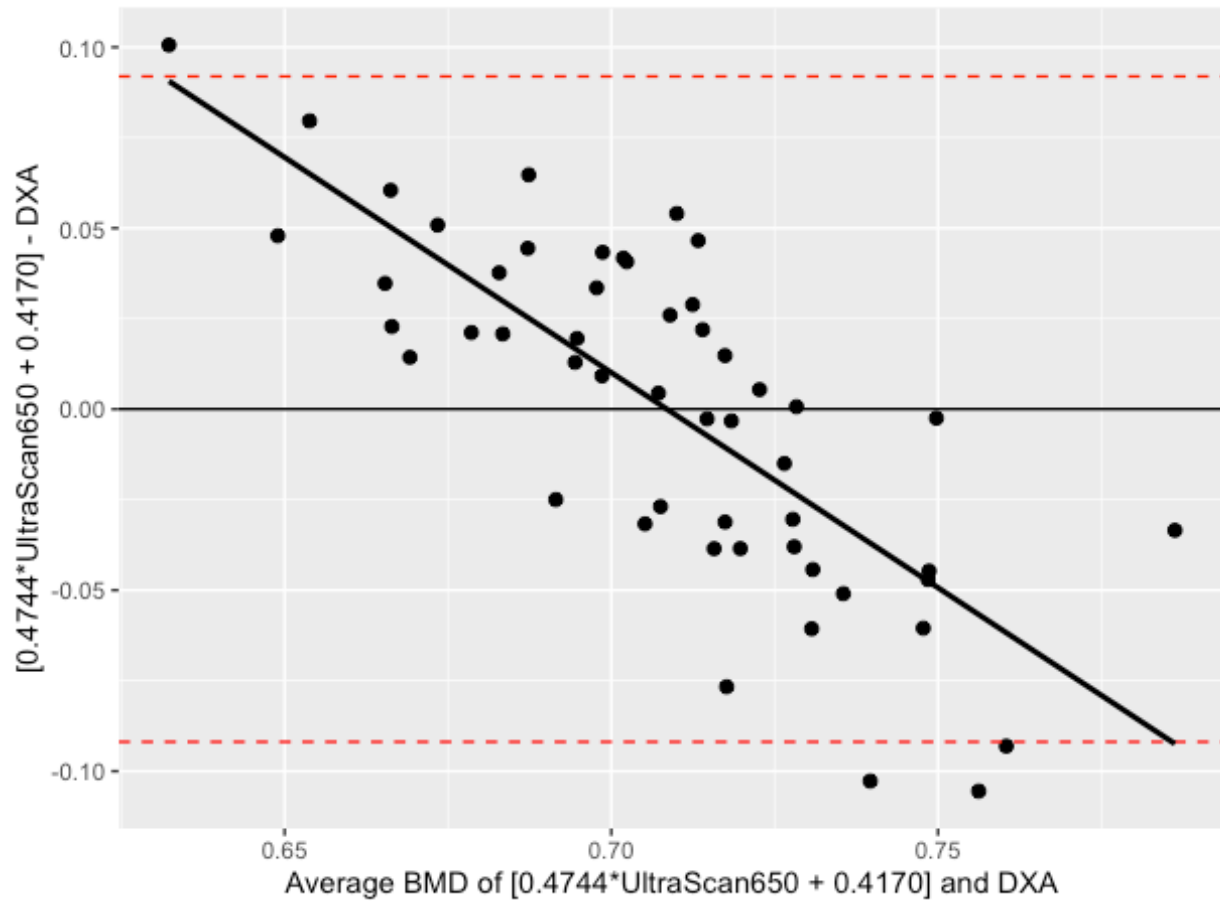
Bland-Altman plot with limits of agreement (LOA) relating the difference between bone mineral density (BMD) as measured by the UltraScan650™ and transformed $[0.4744 \cdot \text{UltraScan650}^{\text{TM}} + 0.4170]$ and dual-energy X-ray absorptiometry (DXA). On the y-axis appears the difference between the transformed UltraScan650™ and the DXA. On the x-axis appears the mean BMD for each participant as measured using the transformed UltraScan650™ and the DXA. A trendline ($r = -0.771$) is present. The dotted lines represent the limits of agreement.
